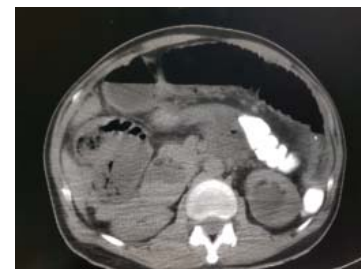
CT abdomen with gastrografin oral contrast showing multiple dilated bowel loops.
